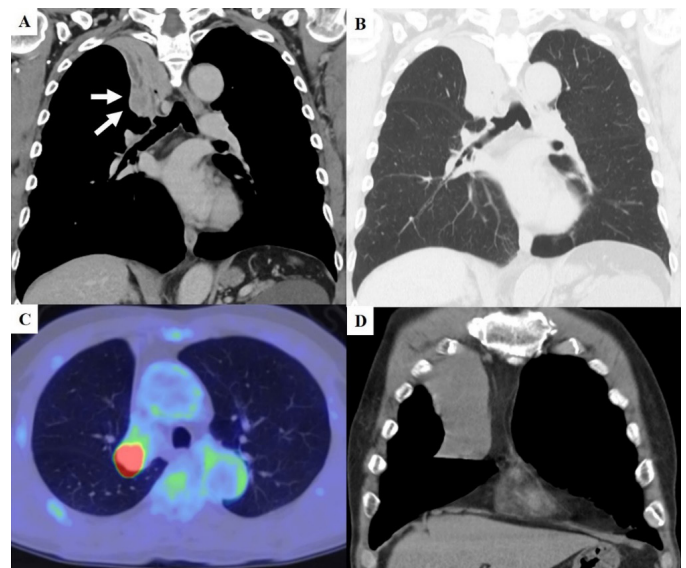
Imaging findings of an 83-year-old man. (A) Mass lesion with suspicion of involve to the right hilar lymph node (#12u) located in the right upper lobe of the lung (arrows). (B) Atelectasis of the right upper lobe. (C) ¹⁸F-Fluoro-2-Deoxy-Glucose (FDG) positron emission tomography showing high FDG uptake in the pulmonary lesion. (D) Worsening atelectasis of the right upper lobe.
